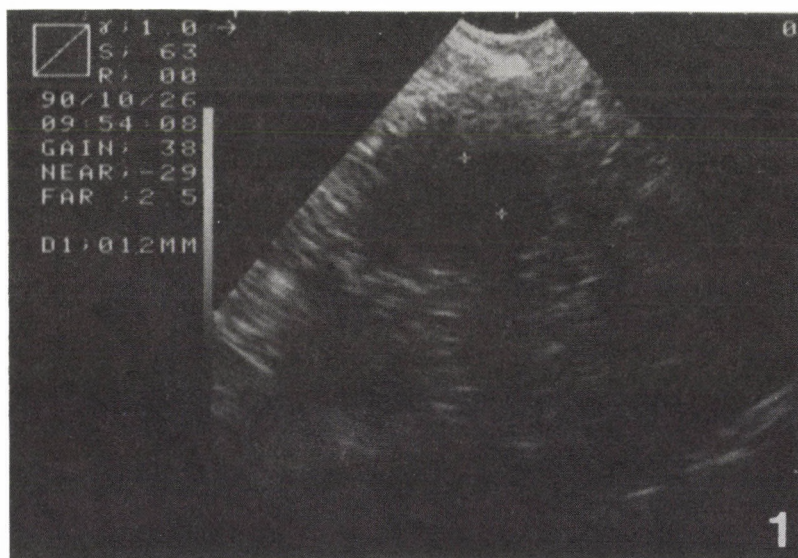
Transvaginal ultrasonic picture of uterine cancer in a 56-year-old woman
